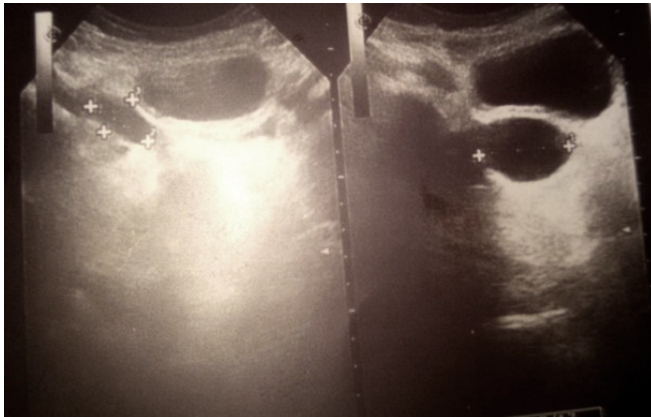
Ultrasonography of the lower abdomen showing two elongate echo-free cysts (56.33 mm and 19.10 mm)
